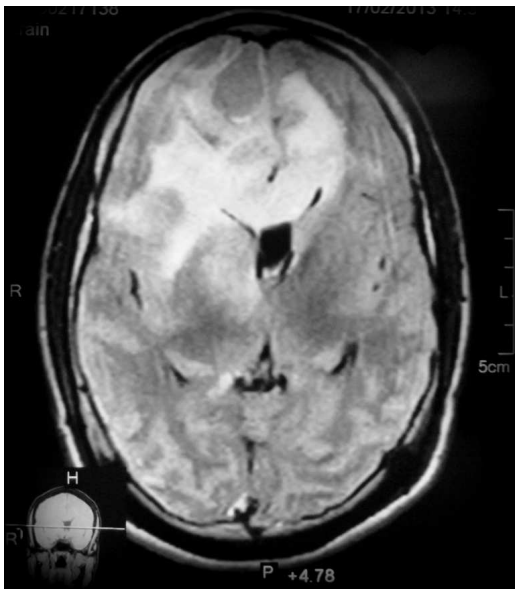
MRI head showing mass occupying right frontal lobe with solid and cystic component and a layer of gliosis over anterior basal part representing an old scar
